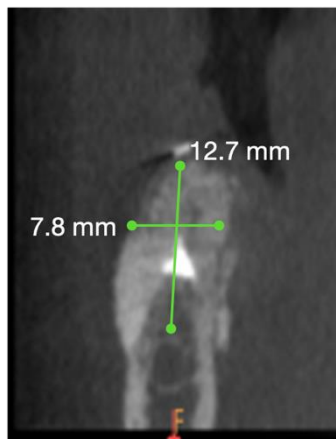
6 months postoperative CBCT to evaluate bone density and volume before implant placement
